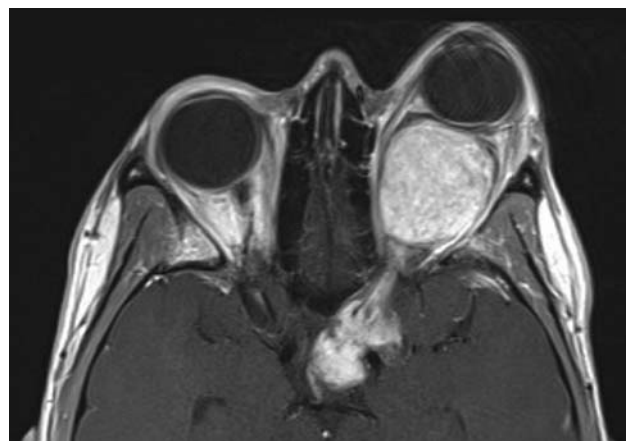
MRI image of a progressive optic pathway glioma causing significant proptosis in a 19-year-old patient.
